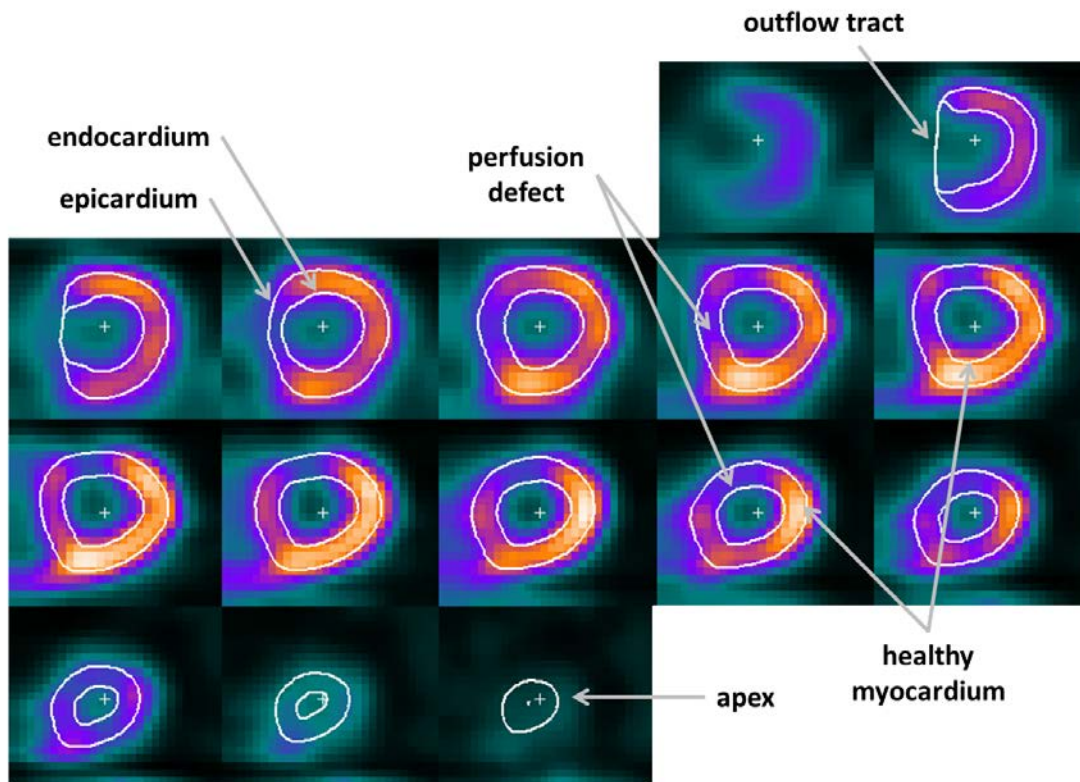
An example left ventricular myocardium segmentation of a patient SPECT MPI study (shown as short axis slices) using the Segment program. The resulting segmentation is represented by the white lines. A number of features of the segmentation and patient data are labeled on the figure: endocardium, epicardium, outflow tract, apex, perfusion defect, and healthy myocardium.
